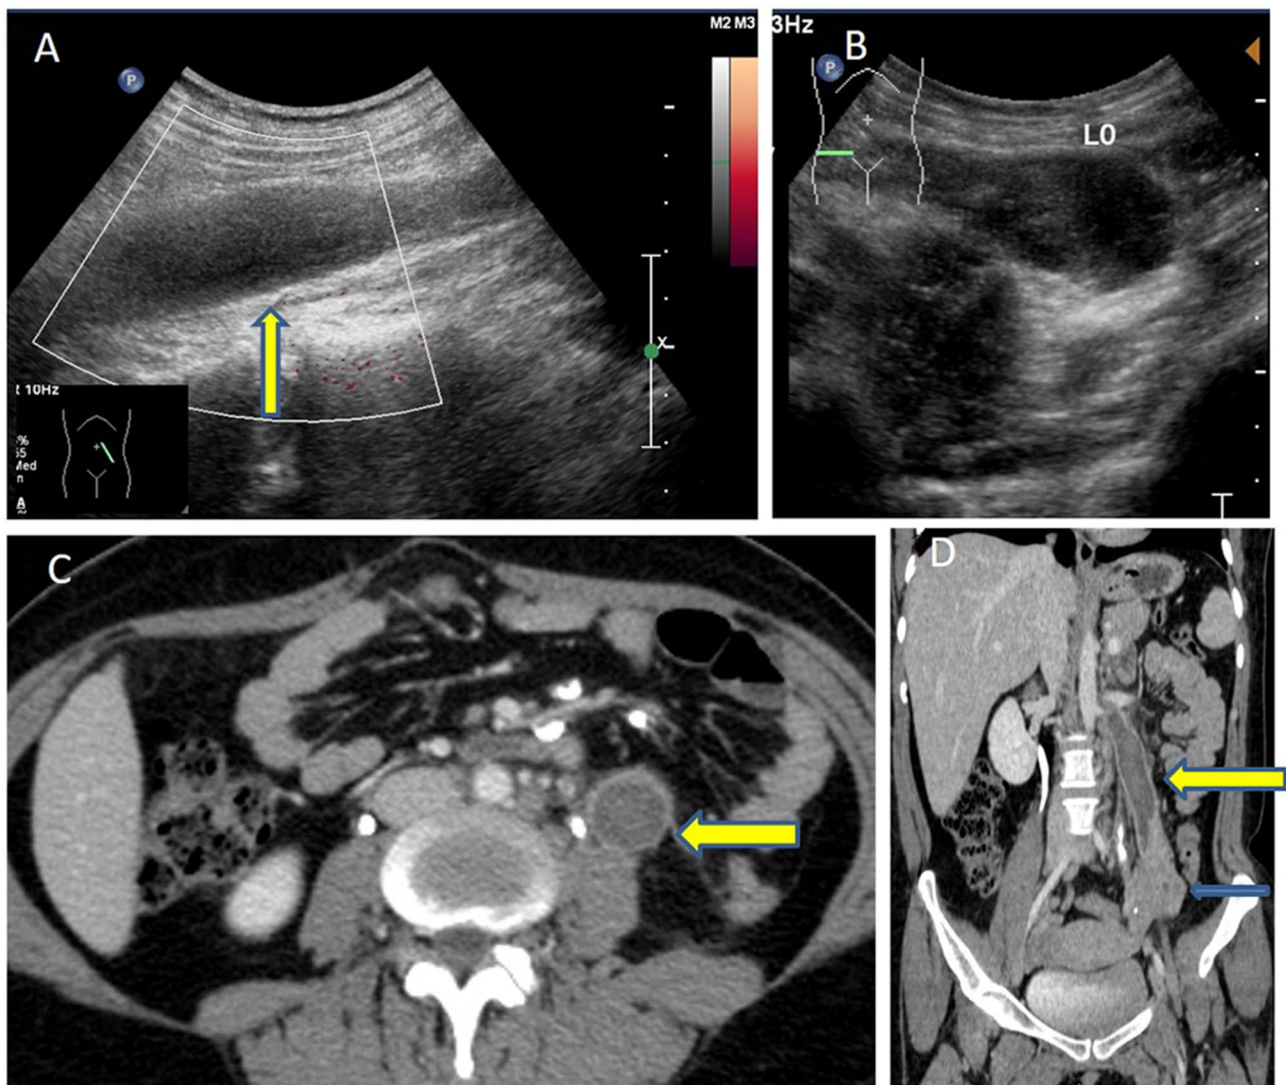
a USG abdomen shows an elongated tubular structure (arrow) with thick walls in left side of abdomen, showing heterogeneous internal contents and no vascularity on color Doppler, b USG pelvis shows enlarged left ovary, c CECT abdomen axial image
